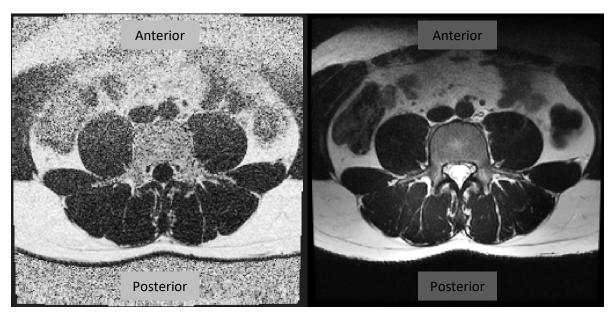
Comparison between a) Dixon fat fraction image and b) T2-weighted image. The fat fraction image shows noise increasing posteriorly-to-anteriorly
